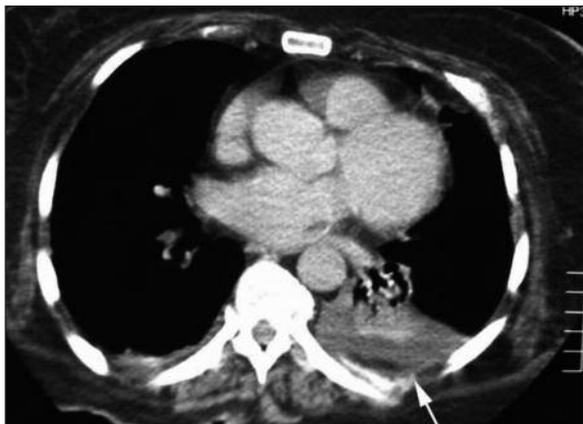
Axial thoracic CT after posterior spinal instrumentation showing marked pleural effusion (white arrow) and left lung atelectasis.
